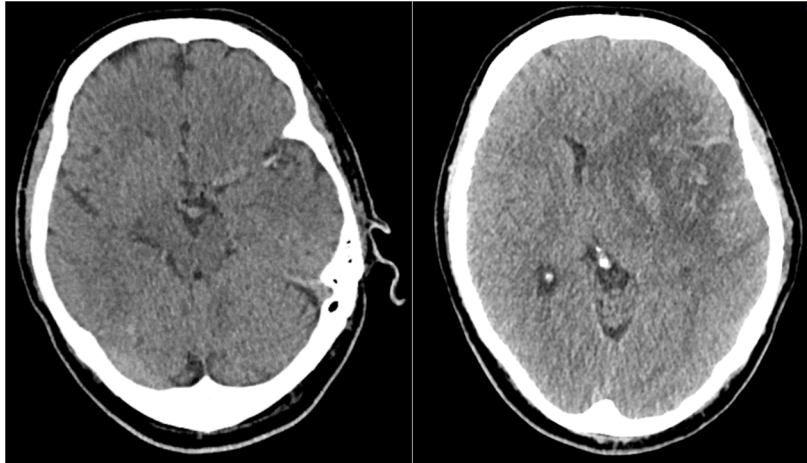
The CT head on the left shows pre thrombolysis CT scan with a hyper-dense left middle cerebral artery sign, and the CT head on the right shows the same patient with a post thrombolysis hemorrhagic transformation.
